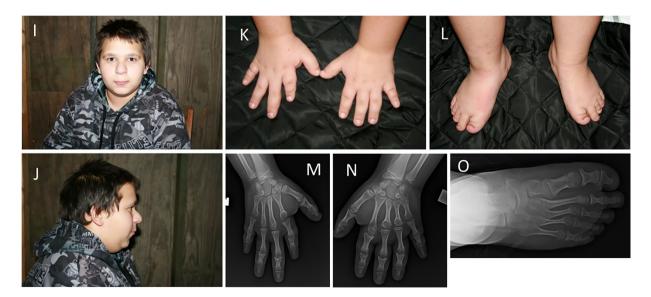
I: Case 2: Craniofacial features include a prominent nose with a bulbous tip J: Lateral image of face reveals retrognathia and low-set ears; K: Hand photographs reveal shortened index and fifth digits L: Feet reveal short polices bilaterally. M,N: X-rays of hands reveal short distal phalanges 1–4, short metacarpals 2 and 5. Wide and irregular MCP joints and cone shape of middle phalanx bases. O: X-rays of feet show a club shaped distal metatarsals with short lateral three rays bilaterally. Short distal phalanges of all toes are noted. [Color figure can be viewed at wileyonlinelibrary.com]
